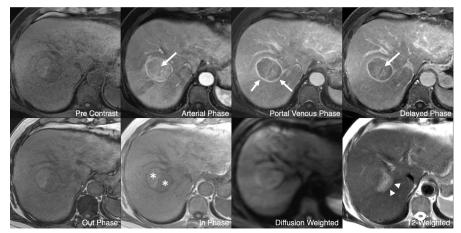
67-year-old man, chronic hepatitis C viral infection, pre- and postcontrast MRI. The combination of size \geq 20 mm and major features (*arrows*: APHE, washout appearance, and capsule appearance) indicates an LR-5 mass (definite HCC). Incidentally, the mass also shows ancillary features favoring malignancy (*arrowheads*: mild-moderate T2 hyperintensity) and HCC in particular (*asterisks*: mosaic appearance), but these ancillary features do not contribute to the category assignment in this case. The mass would be LR-5 even if all these ancillary features were absent.
